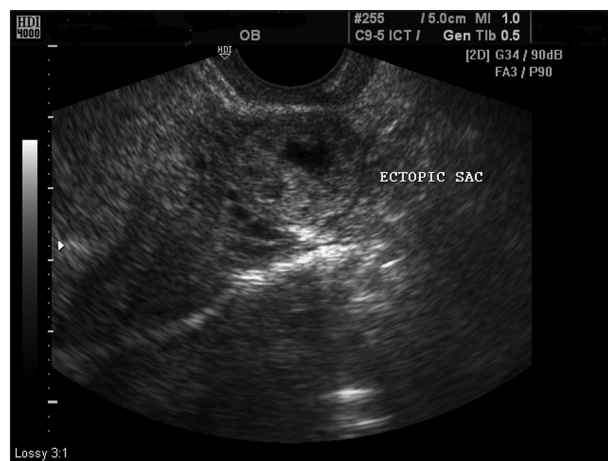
Transvaginal sonography showing ectopic gestational sac in the region of the left adnexa
